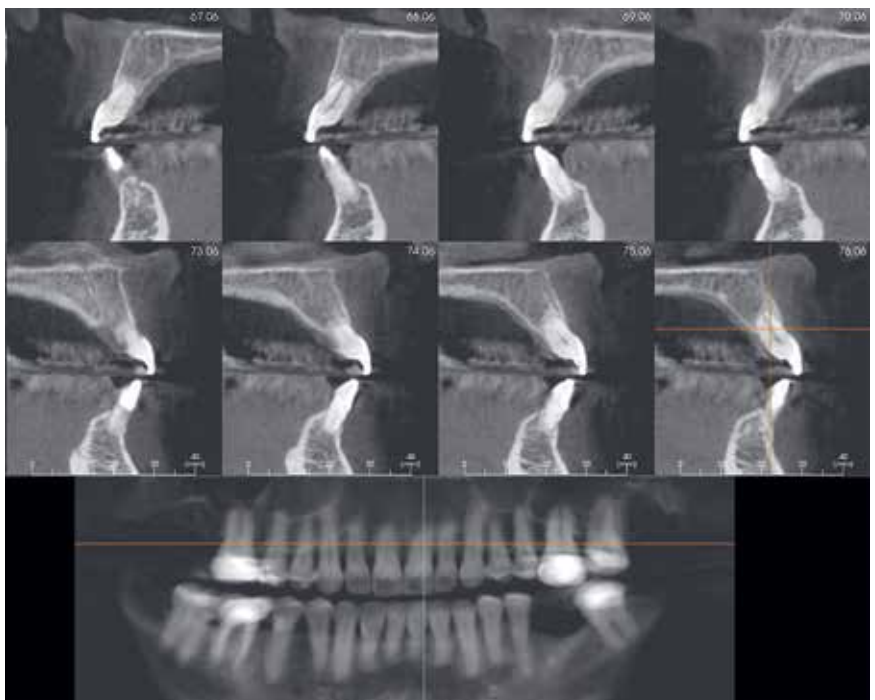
A CBCT panoramic reconstruction (*bottom*) and a series of cross-sectional images (*top*) of the maxilla and mandible showing extensive root resorption on the maxillary and mandibular incisors after orthodontic treatment.
